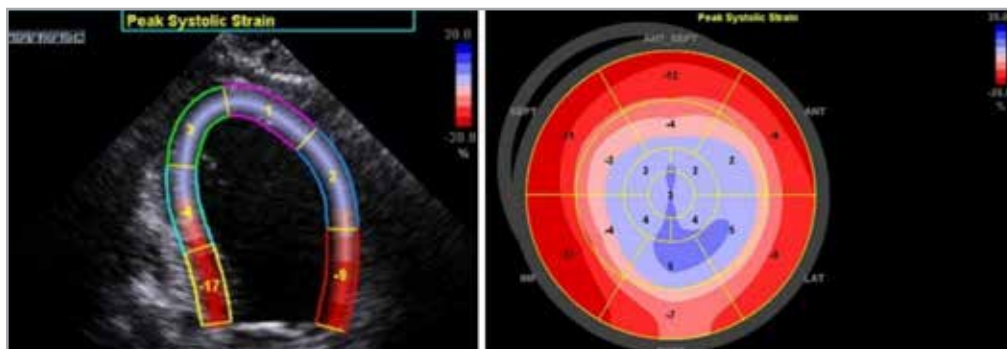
Computer-generated strain values superimposed over apical view on transthoracic echocardiogram (left), demonstrating apical akinesis (lower strain values in blue) with preserved movement of the rest of the ventricle. Computerized rendition of parasternal short axis view with strain patterns again demonstrating apical akinesis (right).
